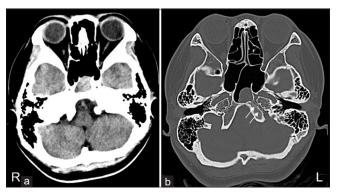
Preoperative computed tomography (CT) findings. Initial CT image on admission showing tumor in the sphenoid sinus (a) and destructive changes in the left petroclival synchondrosis (arrow) (b).
